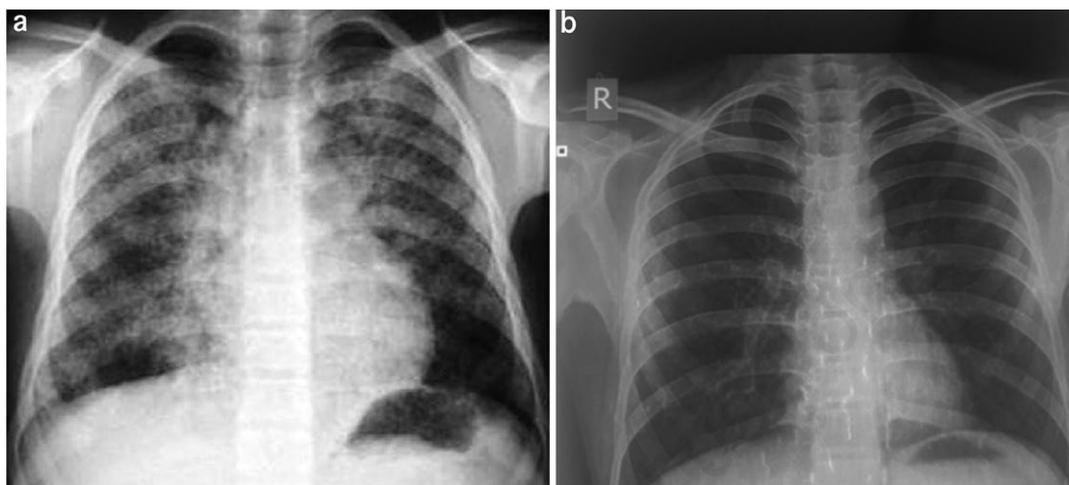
a) Initial chest X-ray on day 1 of admission showing bilateral diffuse opacities subsequently diagnosed as diffuse alveolar hemorrhage. b) Chest X-ray of the patient on discharge after ten days of the initial X-ray showing resolution of diffuse alveolar hemorrhage.
